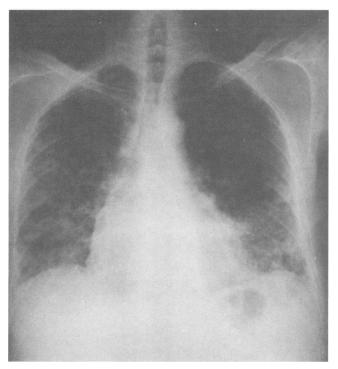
A chest x-ray film taken immediately before an open-lung biopsy shows diffuse bilateral interstitial changes.
